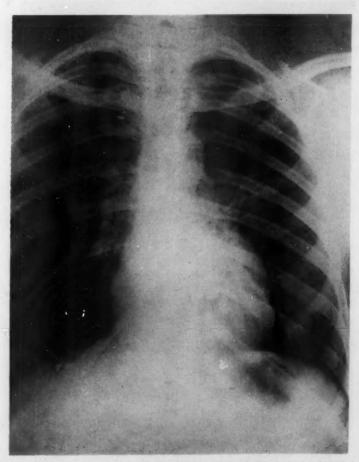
Roentgenogram of chest on discharge from the hospital, showing little change from the initial film.
